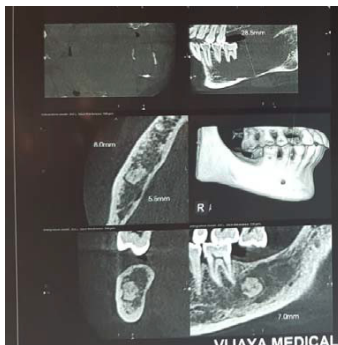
CBCT- a hypodense area involving 35 regions extending towards ascending rami of the mandible
